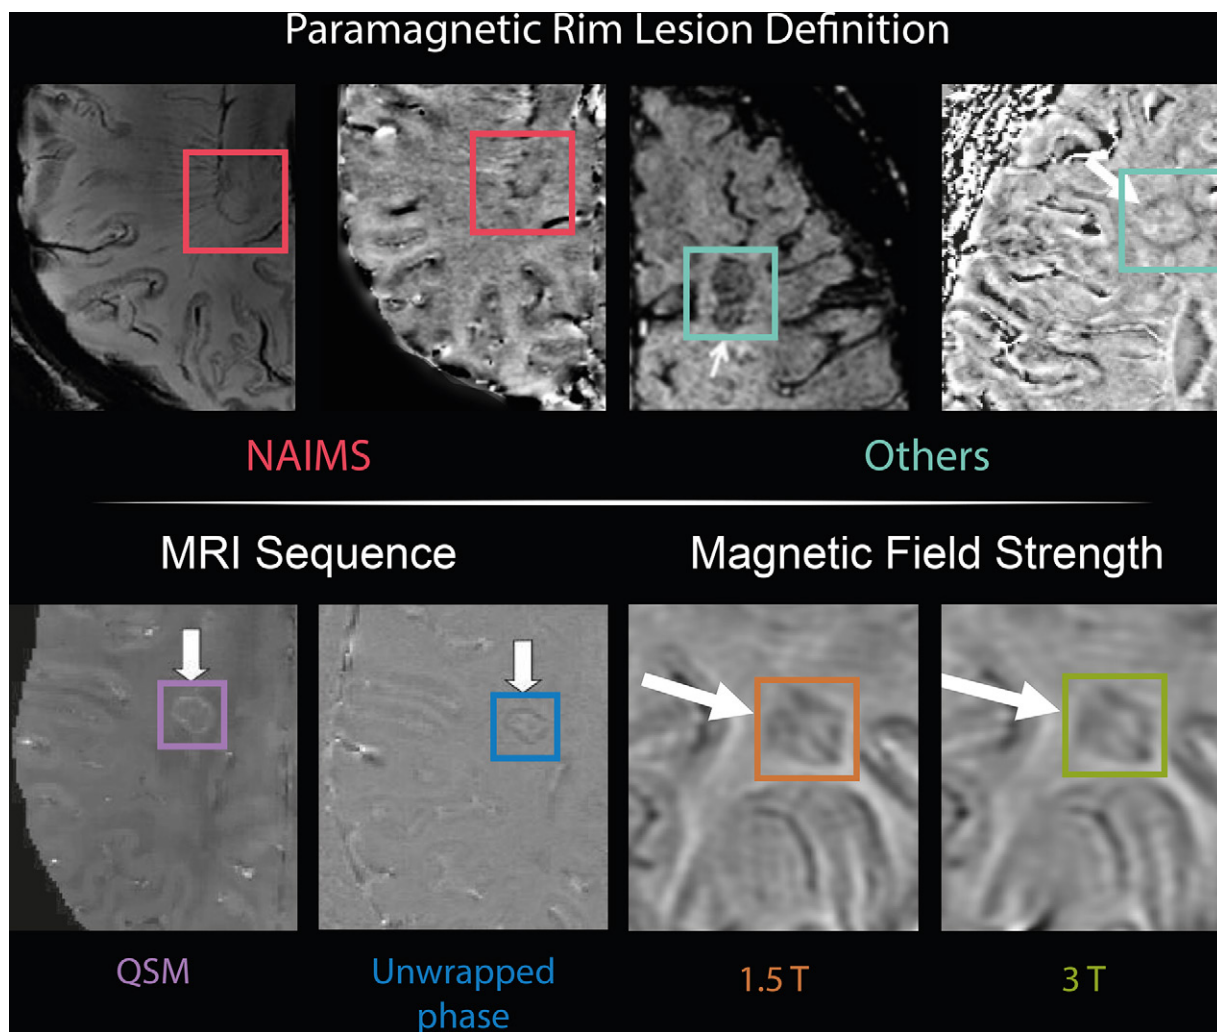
Methodological and technical factors affecting paramagnetic rim lesion (PRL) identification. Example MRI scans in patients with multiple sclerosis (MS) and PRLs identified using different PRL definitions, MRI sequences, and magnetic field strengths are shown. On the top row, red boxes indicate PRLs defined according to the North American Imaging in Multiple Sclerosis (NAIMS) guidelines (left: axial susceptibility-weighted image; right: axial unwrapped phase image) in a 31-year-old with primary progressive MS) [22,36], whereas turquoise boxes highlight PRLs identified using criteria that do not adhere to these guidelines (left: PRL defined as “lesions with peripheral hypointense dots/rims” [42] at the axial postcontrast susceptibility weighted imaging; right: PRL defined as “hypointense rim that surrounds more than 50% of the lesion margin and visible on at least three slices” [43] at the axial susceptibility-weighted imaging–filtered phase) [42,43]. On the bottom row, purple and blue boxes highlight the same PRL identified on axial quantitative susceptibility mapping (QSM) and unwrapped phase images, respectively [16]. Orange and green boxes indicate the same PRL identified in a 28-year-old woman with MS using axial susceptibility-weighted imaging at 1.5 T and 3 T magnetic field strength, respectively [44]. Images were adapted, under a CC BY license, from references 16, 36, 37, and 42–44.
